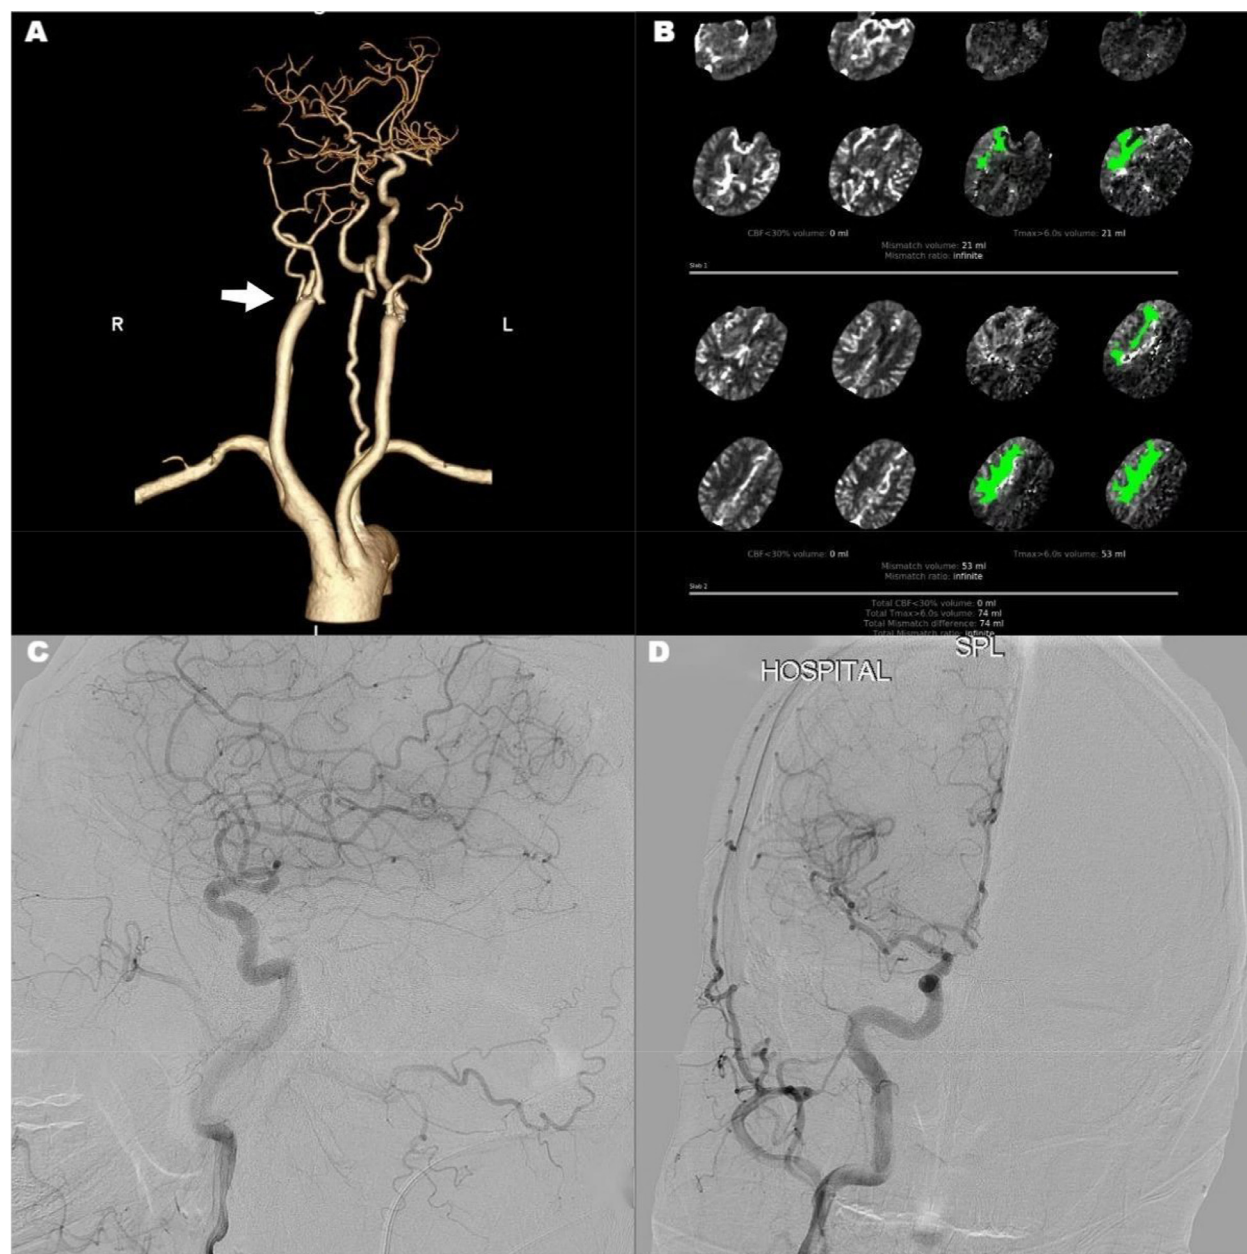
The second mechanical thrombectomy, from A–D, suggested a recurrence of right-side internal carotid artery (arrow) occlusion, a mismatch between CT perfusion ischemia and core infarct size, and blood flow was restored again.
